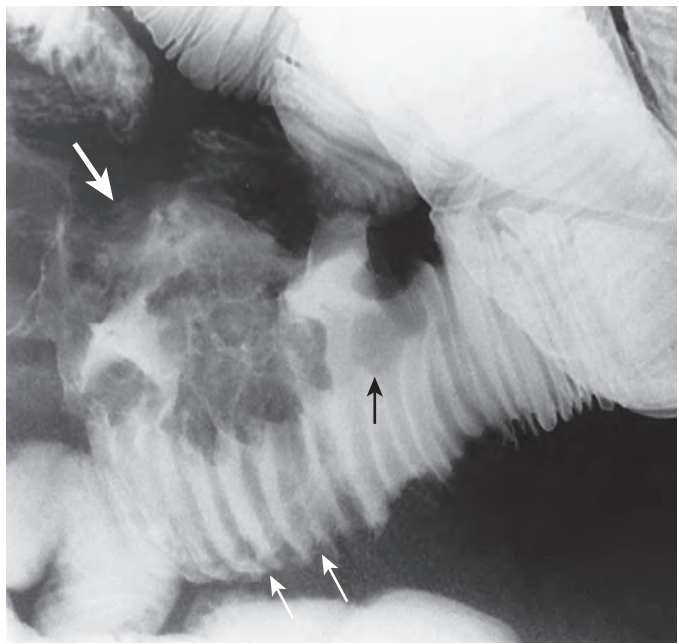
Exoenteric mass: primary lymphoma of the small intestine. A large barium-filled excavation (thick white arrow) projects from the mesenteric border of the small bowel. Note other radiographic findings of primary small bowel lymphoma, including thickened nodular folds (thin white arrows) and mucosal nodularity (black arrow).
